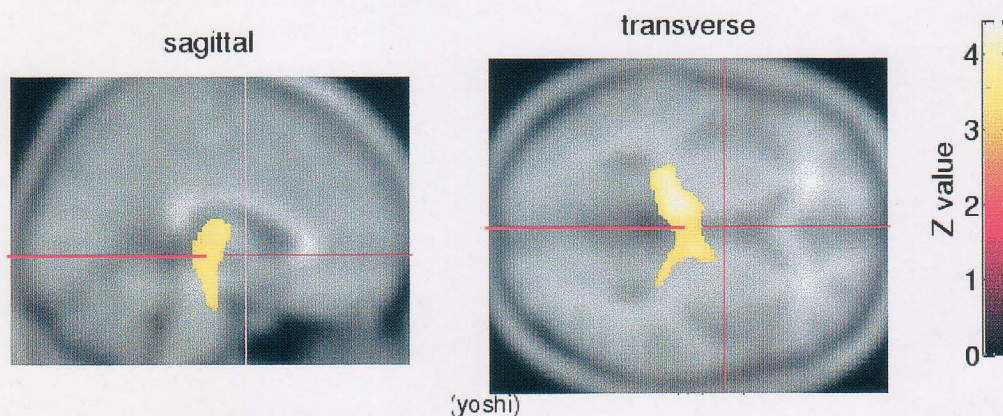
Decreased rCBF is shown in the bilateral thalami and a part of the brain stem (yellow area) of patients with chronic pain on the MRI T1 images.
